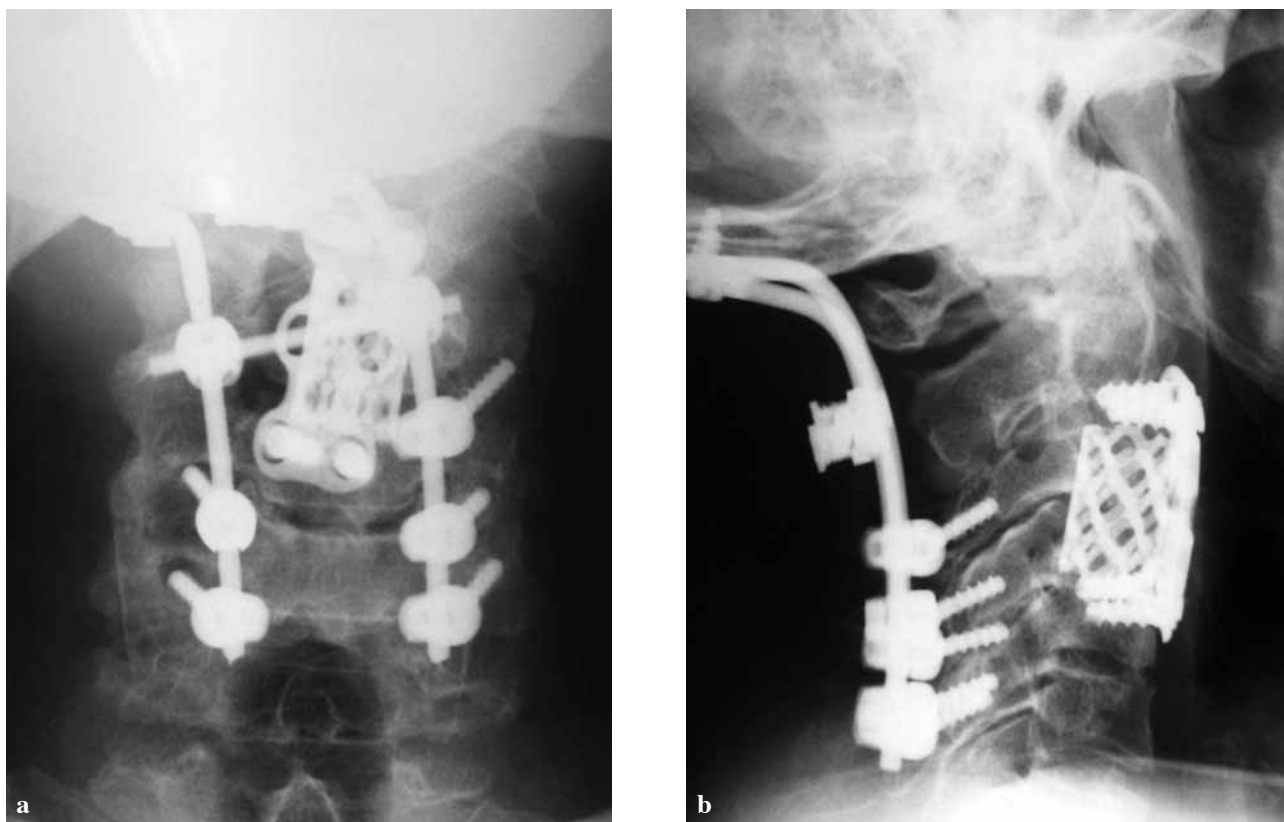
Anteroposterior and lateral plain radiographs, nearly three months postoperatively
